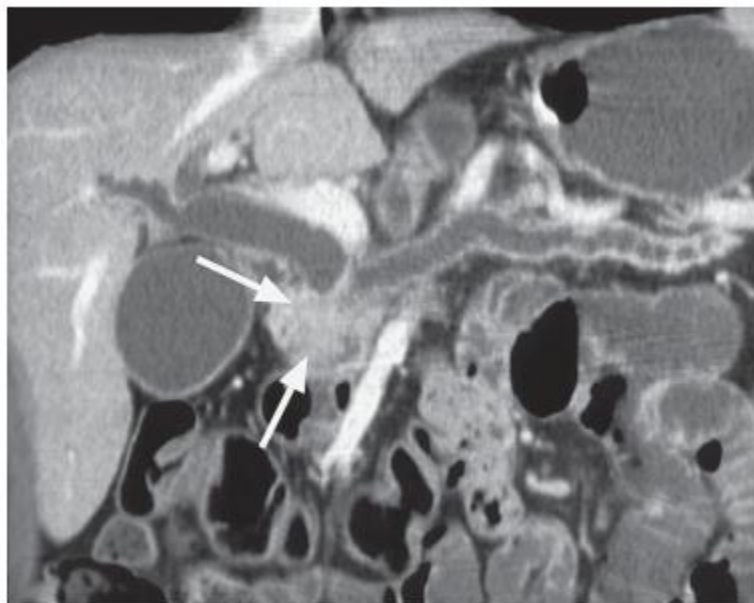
Low biliary obstruction. Multislice CT with curved coronal reformat displaying a pancreatic head tumour (arrows) obstructing the common bile duct and pancreatic duct.
